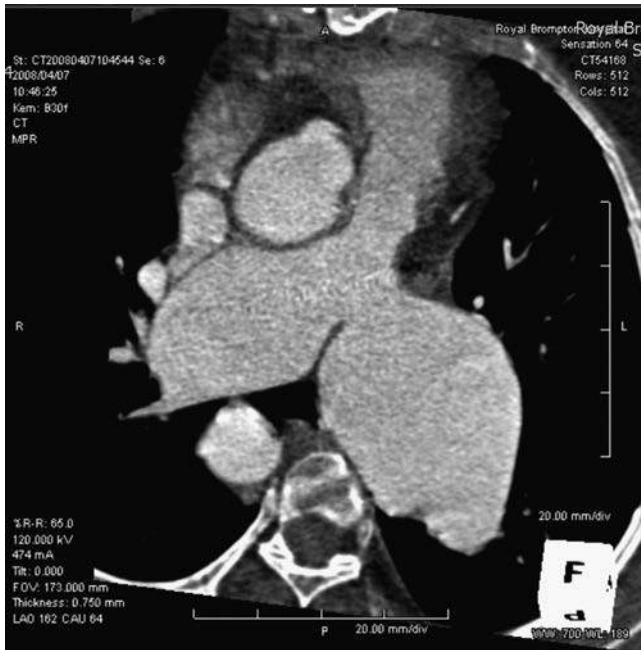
High-resolution computed tomography image demonstrating aneurysmal dilation of the pulmonary arteries. (Courtesy Dr. Michael Rubens, Royal Brompton Hospital, London.)
